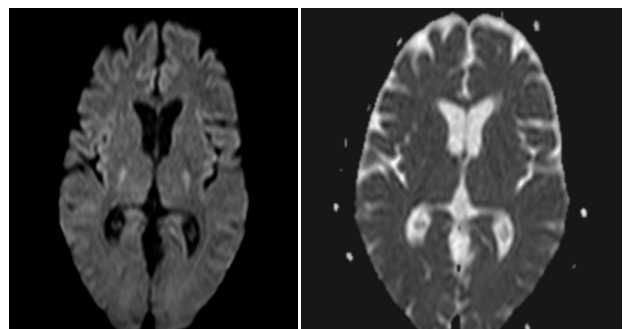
Apparent diffusion coefficient (ADC) and diffusion-weighted imaging (DWI) maps axial sections. There is evidence of restricted diffusion notes in the above-mentioned area.
